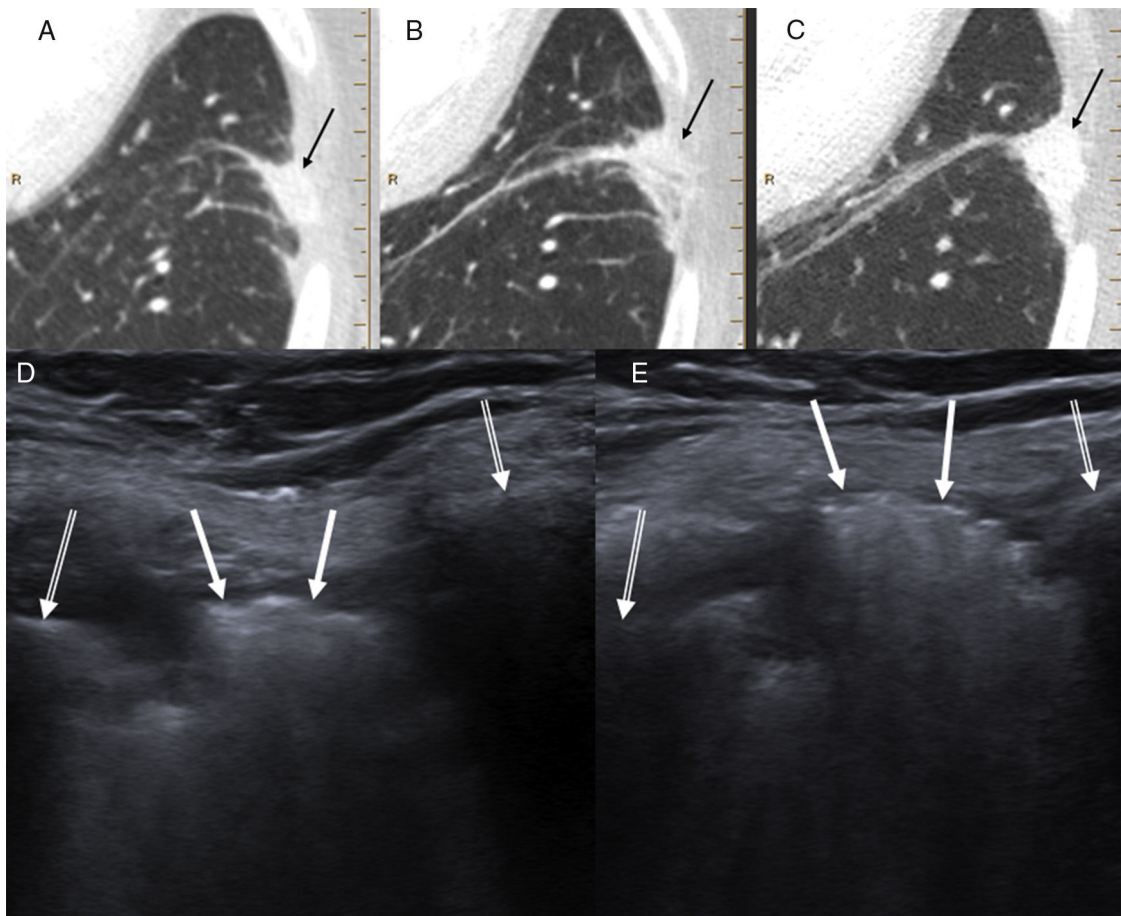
(A–C) Series of follow-up CTs showing a left laterobasal peripheral pulmonary opacity with minor extension to the intercostal space gradually increasing in size and density (black arrows). (D) Chest ultrasound (Valsalva maneuver) showing a hyperechogenic lesion (white arrows) in the intercostal space between the lateral arches of the left seventh and eighth ribs (double white arrows), which mobilized during respiration. (E) Lesion protruding significantly toward the chest wall during the Valsalva maneuver. The patient was diagnosed with intercostal pulmonary hernia probably associated with thoracoscopy entry port for performing left upper lobectomy
